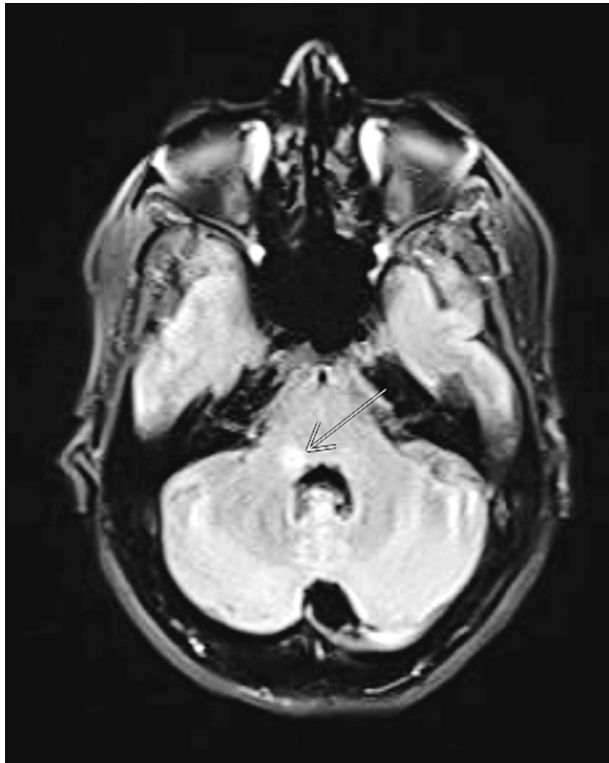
Brain MRI T2-weighted-fluid-attenuated inversion recovery (FLAIR) axial view. There is an oval shaped right middle cerebellar peduncle focus of hyper-intense signal.
